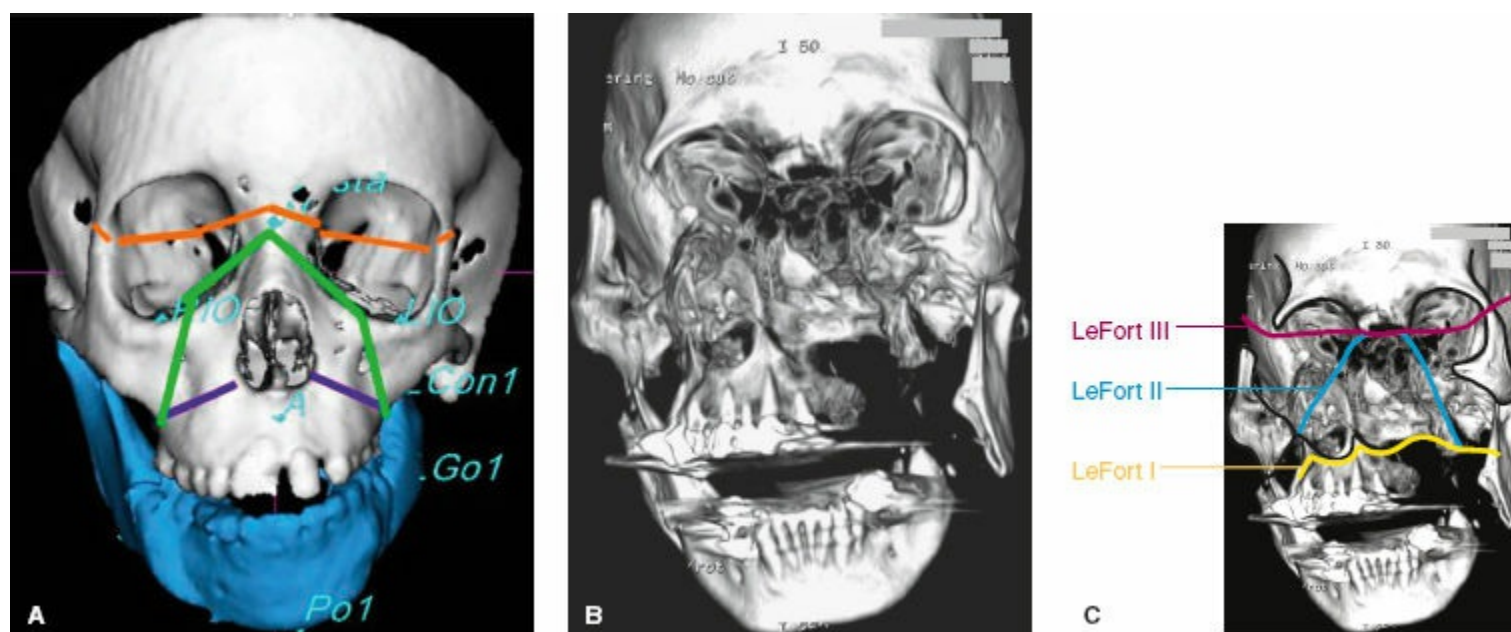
A: Le Fort I fractures are horizontal fractures that span across the piriform rims along the floor of the nose, through the maxillary sinus around to the pterygoid plates posteriorly. Le Fort II fractures are pyramidal in shape and include the nasal bones, infraorbital rims, in addition to the zygomaticomaxillary buttress and pterygoid plates. Le Fort III is a separation of the entire face from the skull base and includes the nasofrontal suture and medial orbit, zygomaticotemporal suture at the lateral orbit around to the pterygoid plates. B,C: Maxillofacial CT of the same patient as above, showing Le Fort I, II, III level fractures and significantly displaced bilateral mandibular body fractures. A CTA and subsequent angiogram showed transection of the bilateral internal maxillary arteries without a target for embolization.
